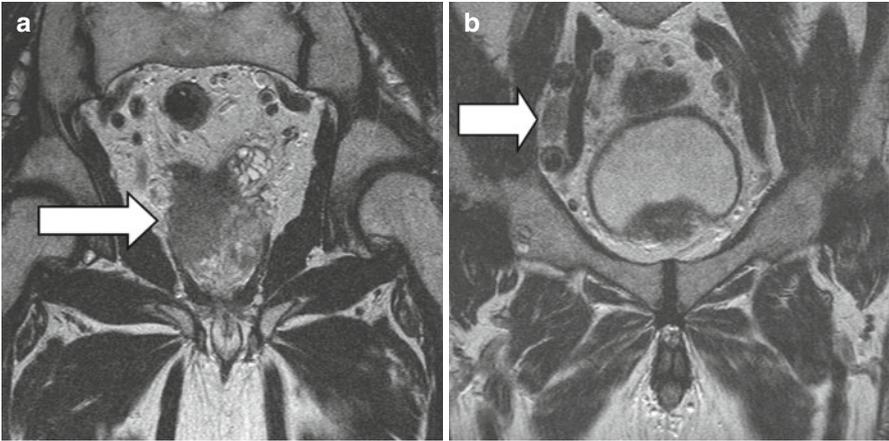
(a, b) Coronal T2 MRI (a) demonstrating large volume right-sided prostate cancer extending into the right seminal vesicle and through the capsule in keeping with T3a and T3b disease. Coronal T2 MRI image (b) through the pelvis demonstrating pathologically enlarged right external iliac lymph node from prostate cancer
